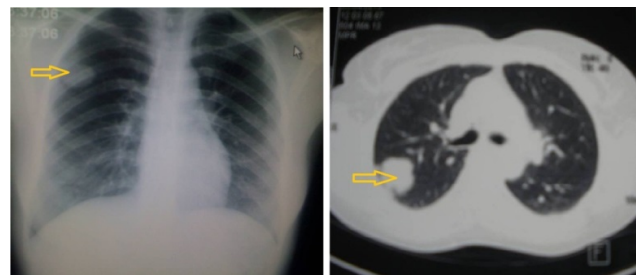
Right upper lung lobe metastatic nodules. (A) At the lung radiography. (B) chest CT scan.
